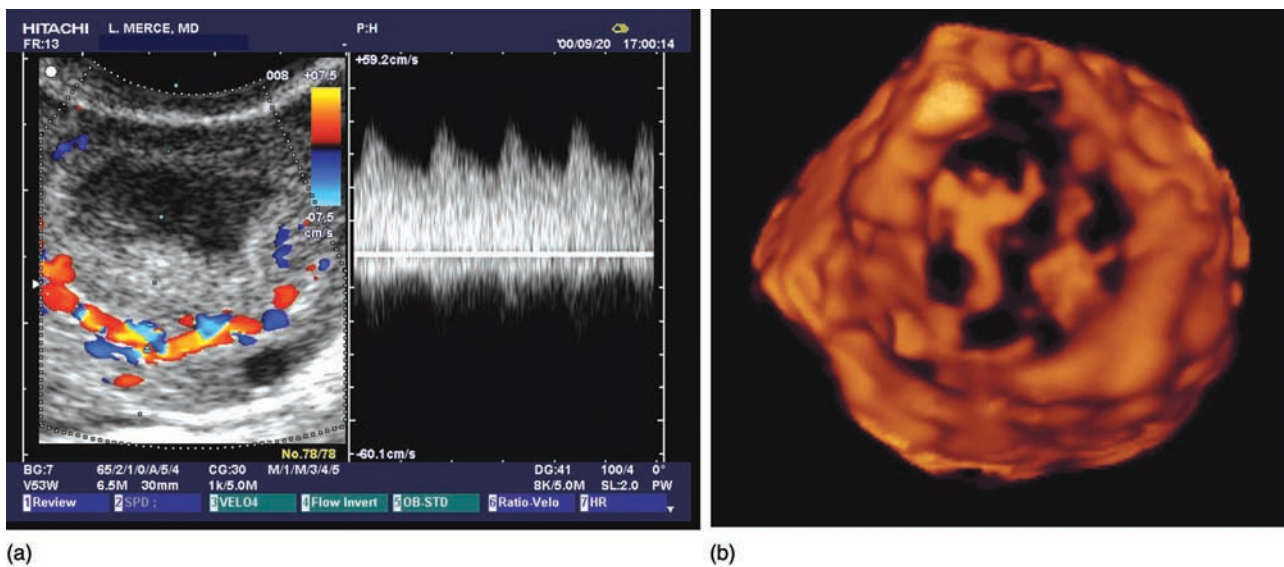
Corpus luteum blood flow study by Doppler technology. (a) Color mapping and FWV during the mesoluteal phase of a normal ovulatory cycle. 'Luteal conversion' is observed. (b) Vascular network of the corpus luteum assessed by 3D power Doppler angiography.
